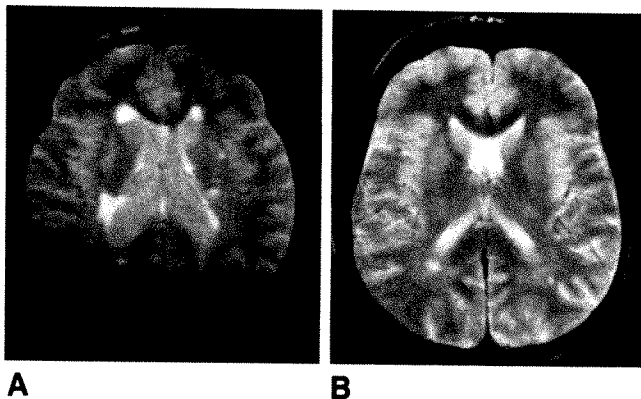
A and B, Comparison of two 1500/100 spin-echo MR images with flip angles of 90° (A) and 65° (B) at about same brain level in two patients with multiple sclerosis. B has more T2-weighted contrast than A.
